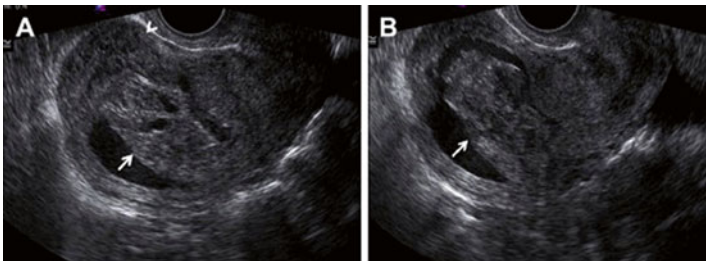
Partial hydatidiform mole. Grayscale sonographic images of the uterus demonstrate cystic changes within the placenta (arrowhead in a) and an abnormal nonviable fetus (arrows in a and b) (Reprinted from Shanbhogue et al. [12], with permission from Elsevier)
